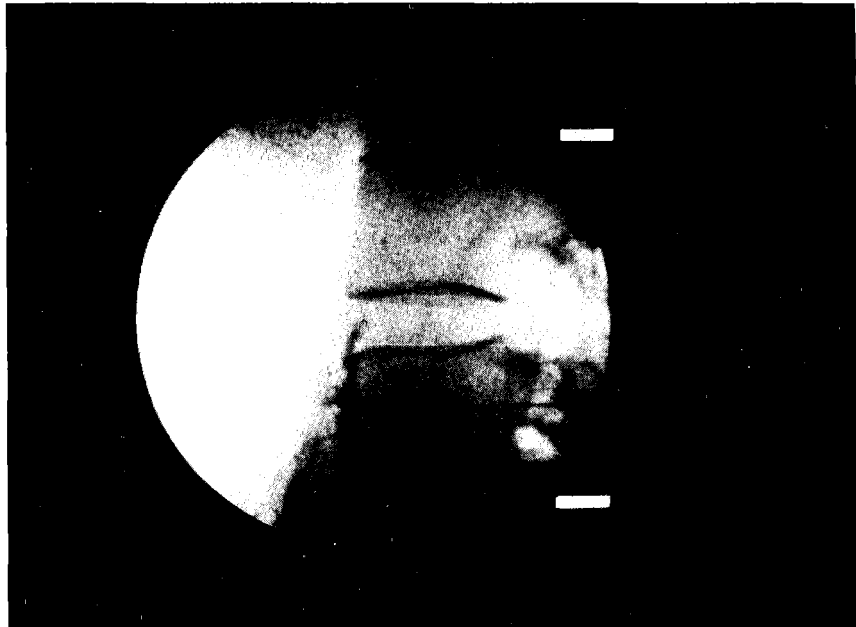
X-ray; lateral view + contrast
